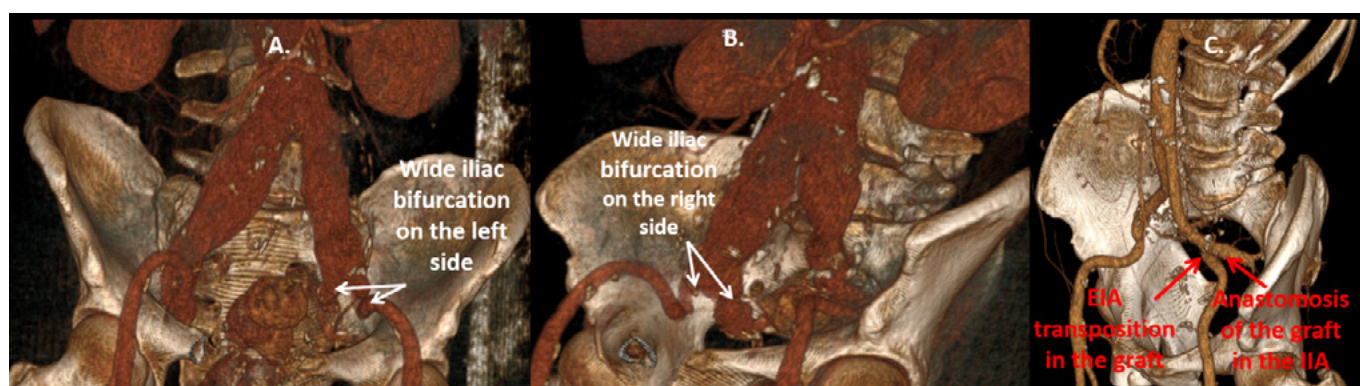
3-Dimensional reconstruction indicating wide iliac bifurcations on left (3A) and right (3B) side and the postoperative CT scan (3C) of the 3rd case.
